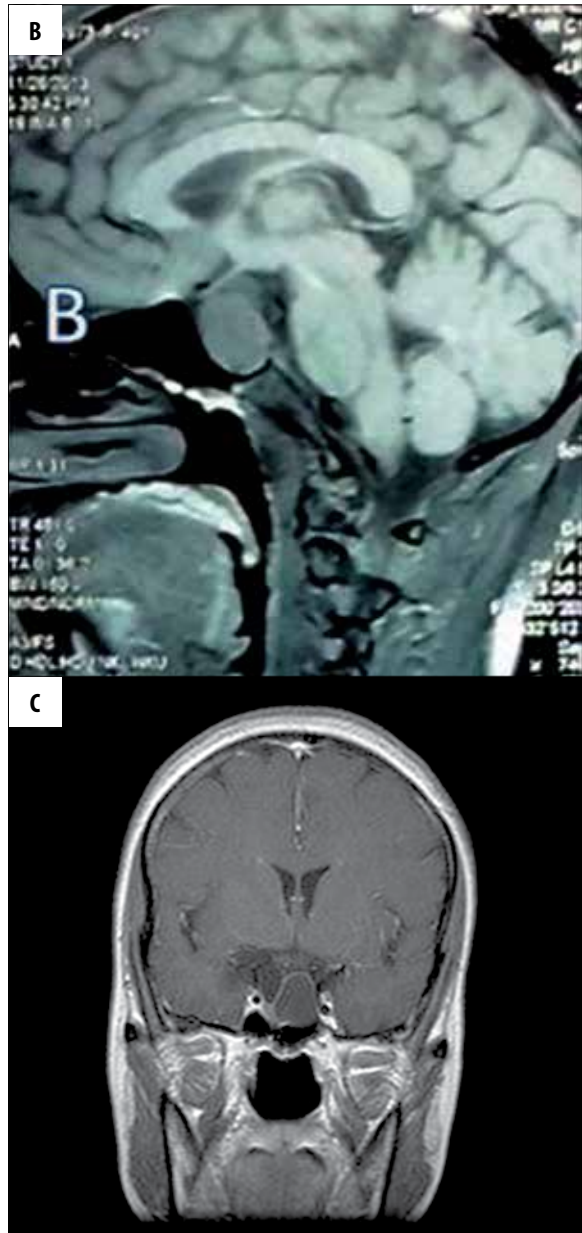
Axial (A) and sagittal (B) T1-weighted MR images of the brain showing a hypointense signal similar to CSF in major portion of the sellar and suprasellar lesion with a thin septum. A part of the lesion on the left side of the septum shows a hyperintense signal. Coronal post-contrast T1-weighted image (C) of the brain showing non-enhancement in major portion of the lesion with smooth, thin rim enhancement in the left-sided locule.
